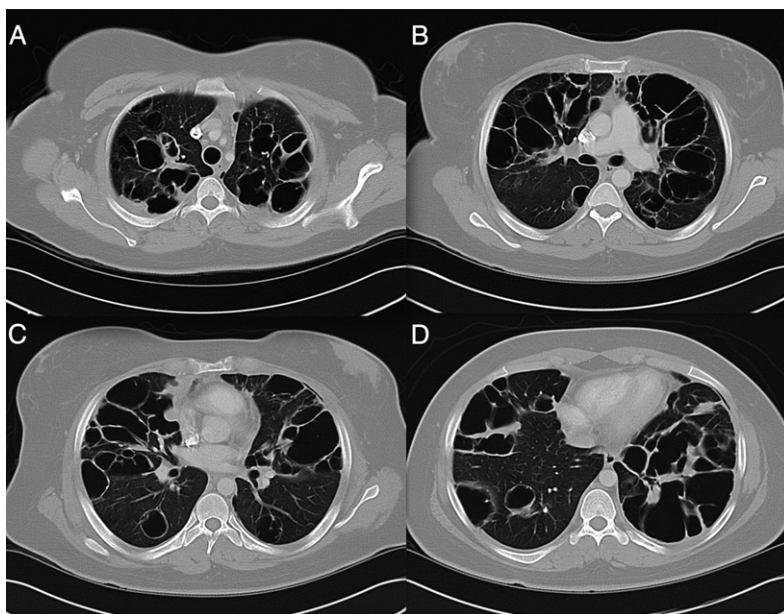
A-D, Serial transverse cuts of chest CT scan showing irregular thin- and thick-walled cysts, some large and consisting of several coalescent cysts, present in both lungs, with upper and middle lung zone predominance and relative sparing of the lung bases.
